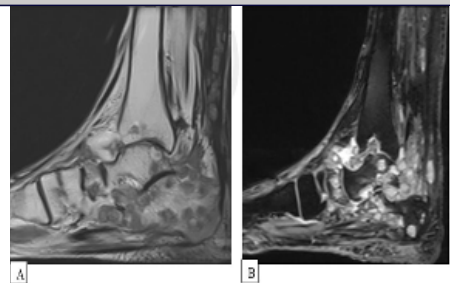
(A & B): MRI of the left ankle & foot T1 & T2 FS shows multiple well defined variable sized contrast T1 hypointense. T2 FS hyperintense lesions showing "Dot-in-circle" sign.
